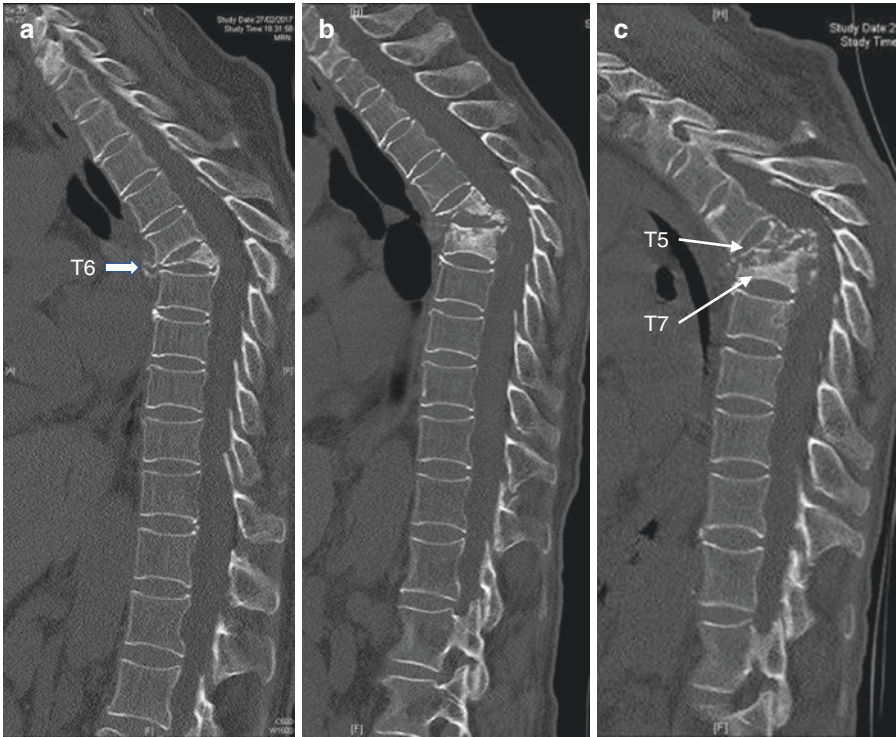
(a–c) Sagittal reconstructed CT scans showing the progressive anterior column destruction. (a) Only T6 was infected by TB and collapsed. (b) T5–T7 collapsed 1 year later. (c) T5–T7 collapsed further with increasing kyphosis in 2 years
